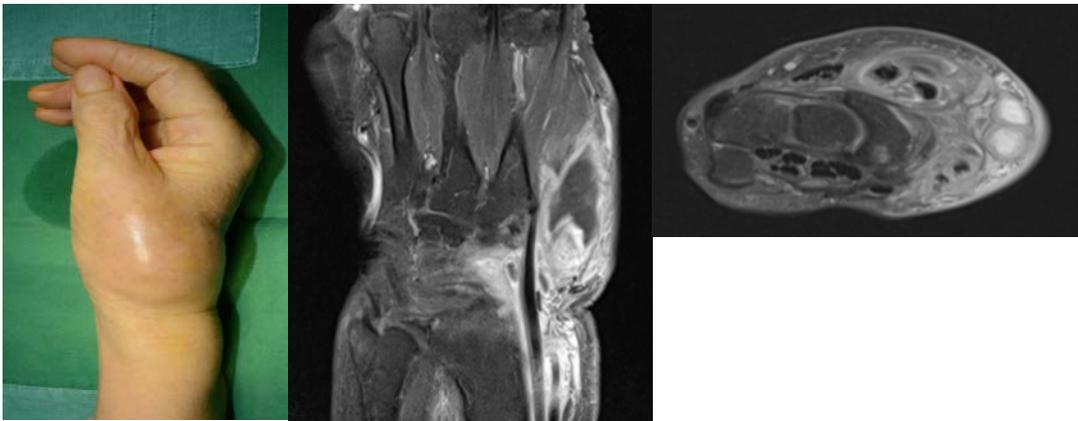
80-year-old female patient. 1st carpometacarpal joint (CMC) swelling and redness were observed. Pre-operative magnetic resonance imaging shows large cavitory lesion with thin peripheral rim enhancement along EPL & EPB tendons and marked enlargement of ECRL, ECRB and APL, suggest infectious tenosynovitis. Bone marrow edema and osteomyelitis with joint involvement.
